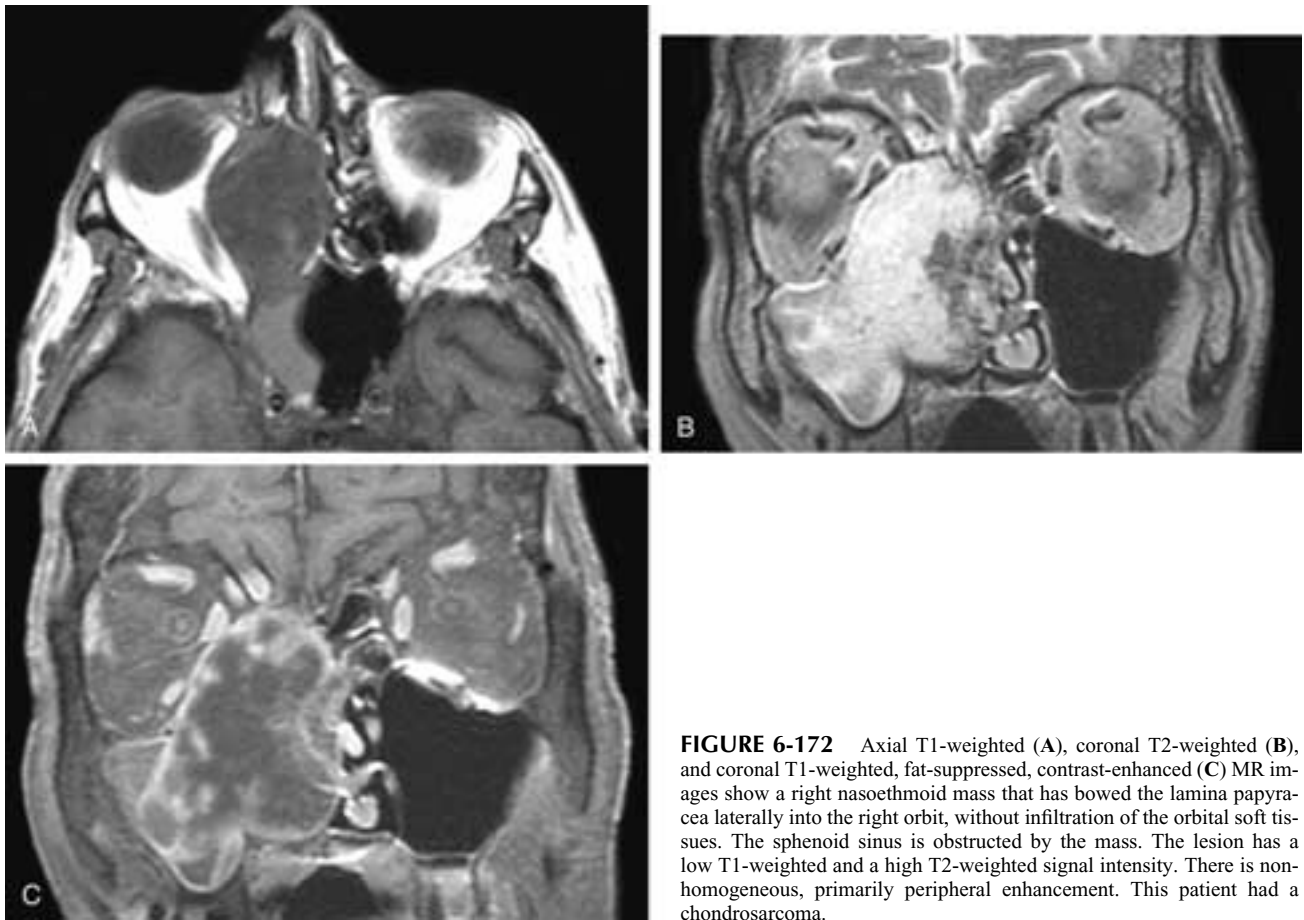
Axial T1-weighted (A), coronal T2-weighted (B), and coronal T1-weighted, fat-suppressed, contrast-enhanced (C) MR images show a right nasosethmoid mass that has bowed the lamina papyracea laterally into the right orbit, without infiltration of the orbital soft tissues. The sphenoid sinus is obstructed by the mass. The lesion has a low T1-weighted and a high T2-weighted signal intensity. There is non-homogeneous, primarily peripheral enhancement. This patient had a chondrosarcoma.
